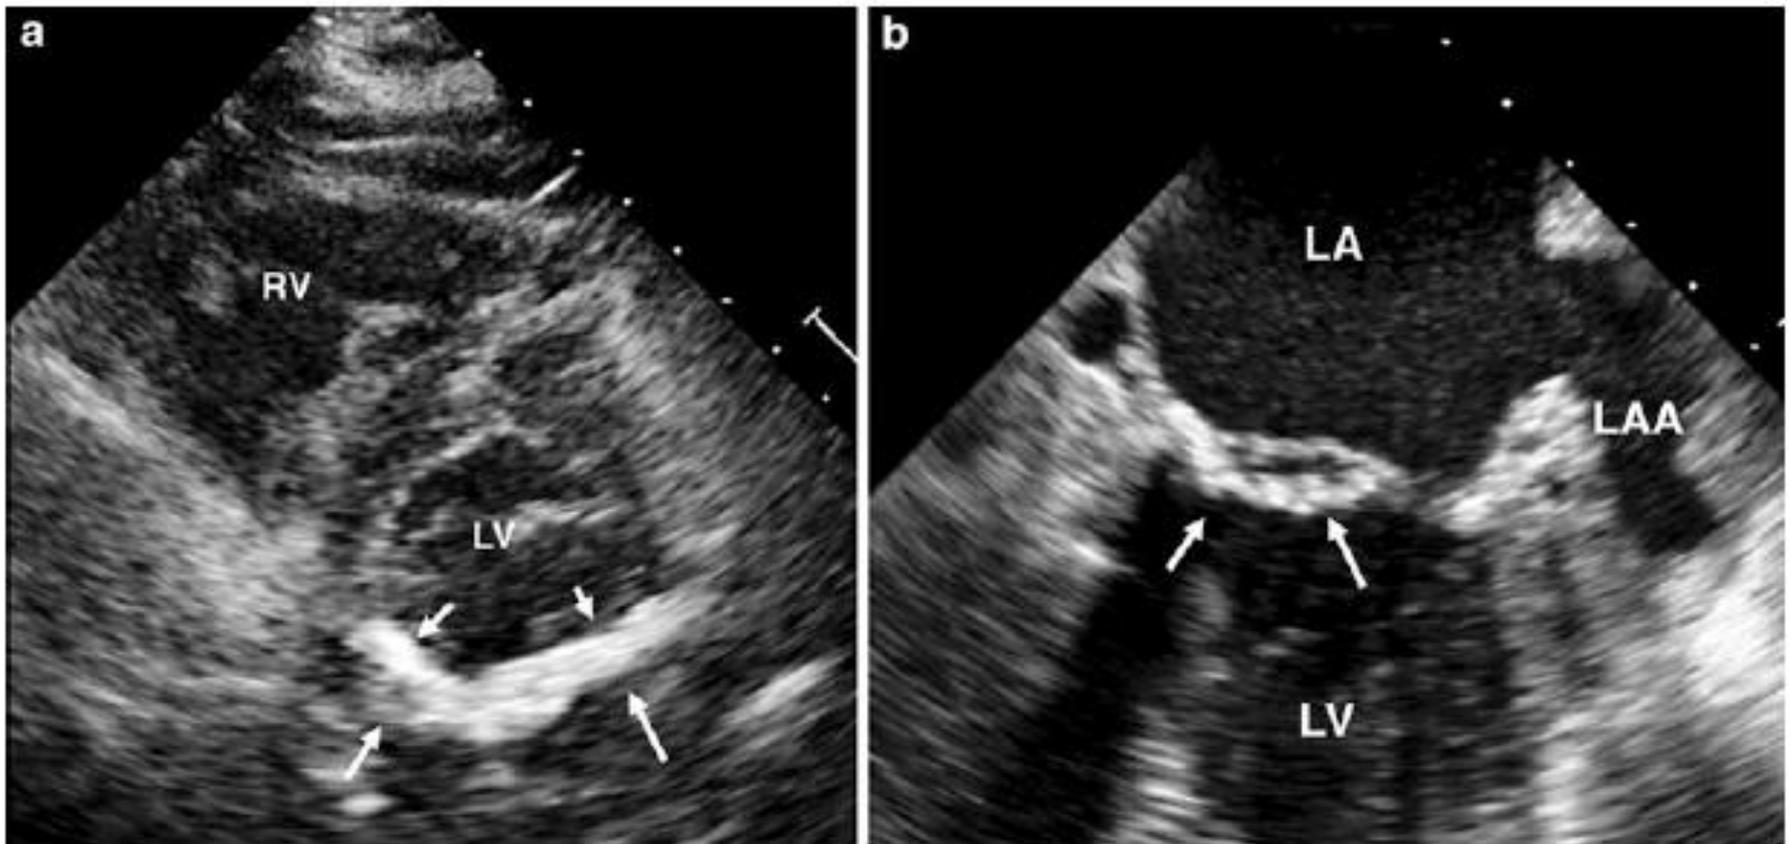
a Transthoracic parasternal short-axis slice showing widespread calcification extending to the entire posterior annulus; b transesophageal two-chamber slice
